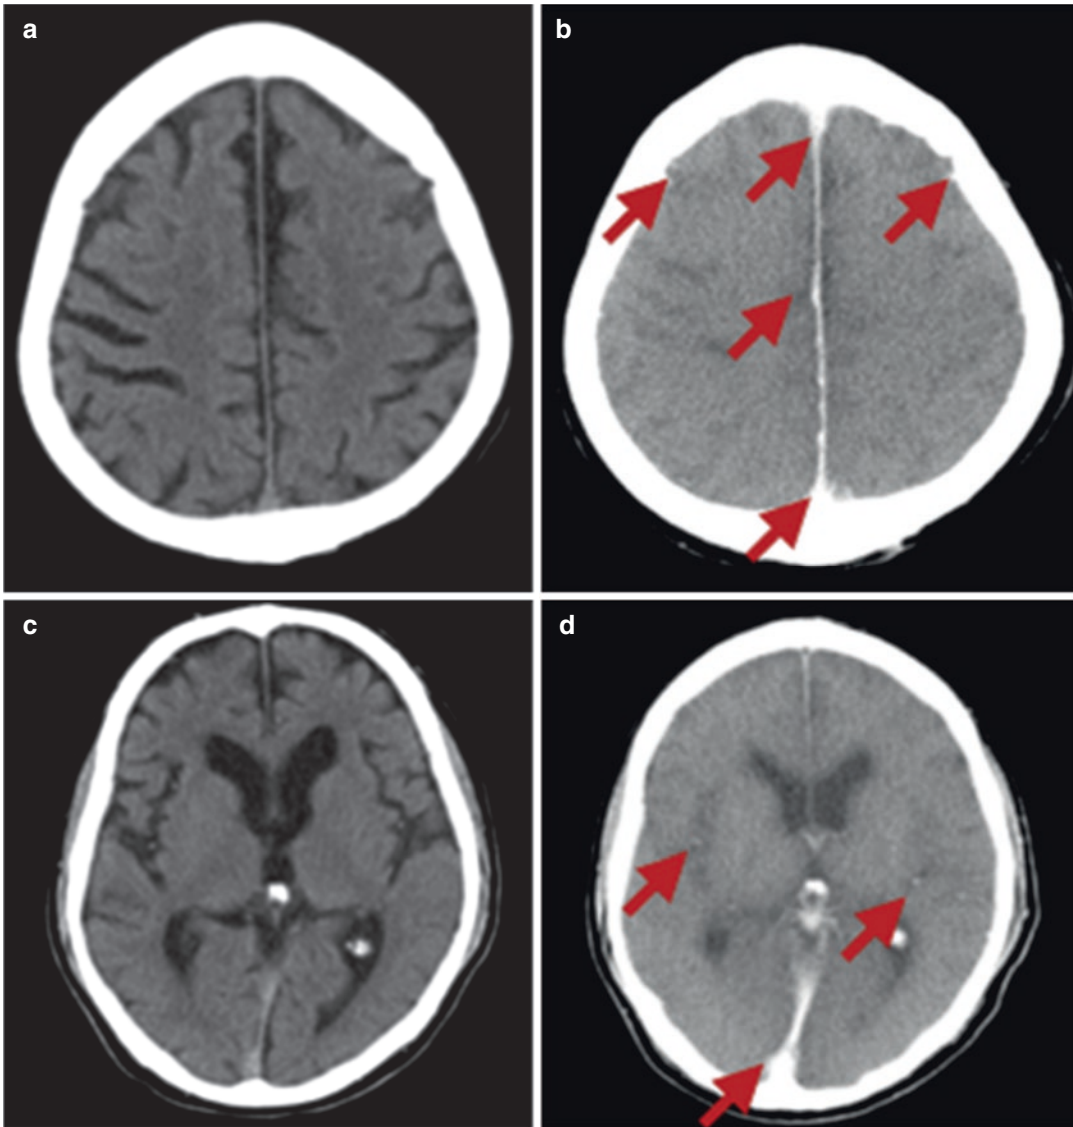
Antemortem (a, c) and postmortem (b, d) brain computed tomography (CT) images at a similar section level of the same subject who died due to hanging. The decreased gray matter/white matter contrast and brain
